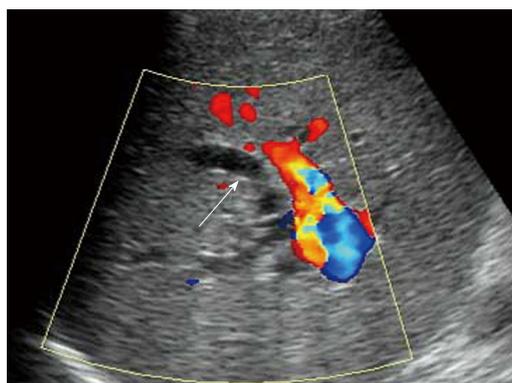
Moderate intrahepatic biliary dilatation (arrow) was shown by the follow-up ultrasound in a 34-year-old man four mos after dual-graft liver transplantation.
